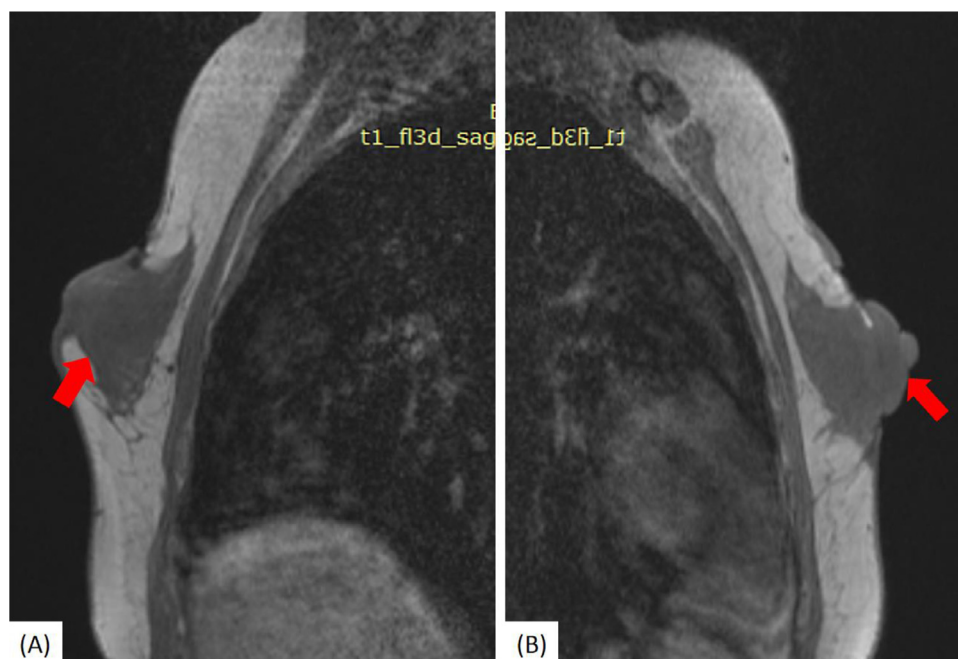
Sagittal T1-weighted images of the right (A) and left (B) breast demonstrate low-signal intensity area (arrows) of the injected mixture indistinguishable from breast tissue.
